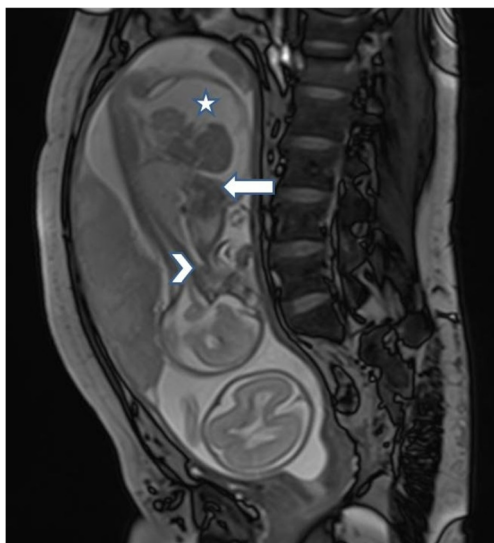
Fetal MRI in twin pregnancy (32 wk gestation) showing one fetus with features of CHAOS. *Arrow* pointing at the inverted diaphragm, *arrow head* showing the abrupt cut-off of trachea till the subglottis and the star showing fetal ascitis. The postnatal diagnosis was congenital tracheal atresia
